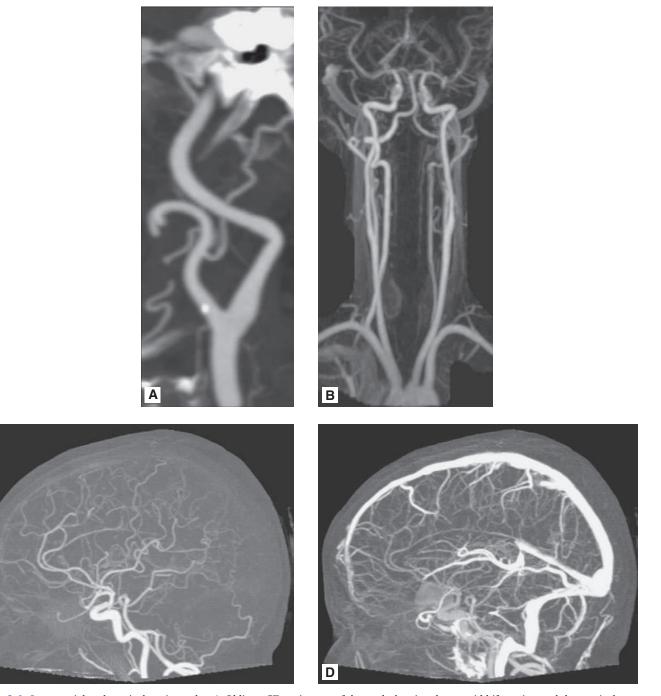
Intracranial and cervical angiography. *A*. Oblique CT angiogram of the neck showing the carotid bifurcation and the cervical segments of the internal and external carotid arteries. Note the slightly dilated carotid bulb at the initial segment of the internal carotid artery. A small focus of calcified atherosclerosis is noted near the origin of the external carotid artery. Note that the external carotid artery has multiple branches within the neck. *B*. Coronal MR angiogram of the neck showing the aortic arch, the origins and cervical courses of the carotid and vertebral arteries, and the vertebrobasilar junction. The sigmoid sinuses and internal jugular veins are faintly visible. *C-D*. Sagittal dynamic CT angiography of the head. Bony and soft tissue structures as well as brain parenchyma have been digitally subtracted. The image *C* was acquired during the arterial phase; the carotid and basilar termini and the anterior cerebral arteries are enhanced. Venous phase imaging (*D*) shows enhancement of the superior and inferior sagittal sinuses, straight sinus, vein of Galen, internal cerebral veins, basal veins of Rosenthal, and the transverse and sigmoid sinuses.
